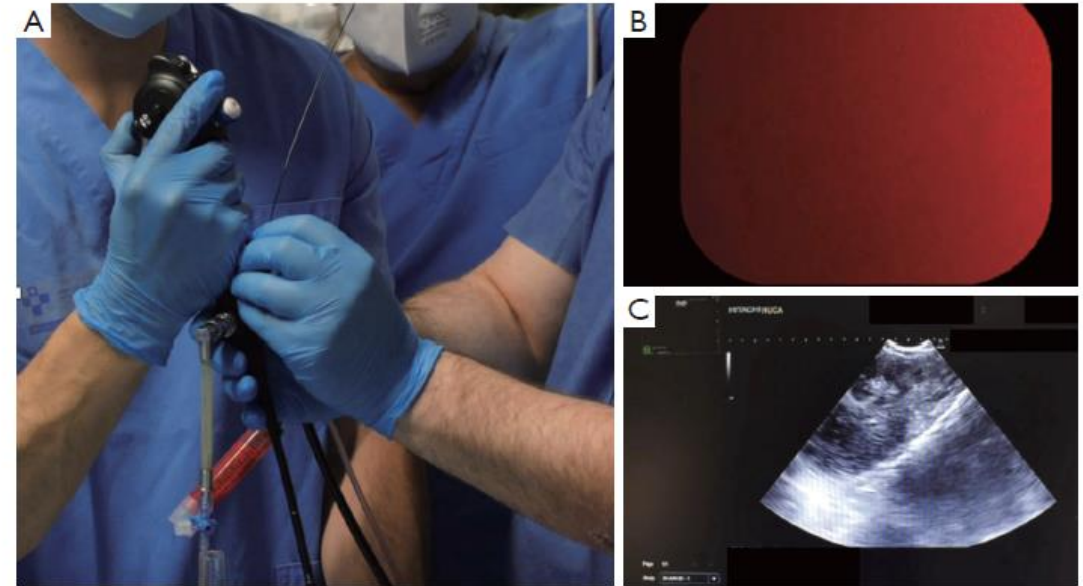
Introduction of the cryoprobe. (A) 1.1 mm cryoprobe being introduced gently into the working channel of the EBUS bronchoscope. (B) No endoscopic vision for letting us locate the previous puncture site. (C) Ultrasound image showing the needle trace inside the lymph node. EBUS, endobronchial ultrasound.
